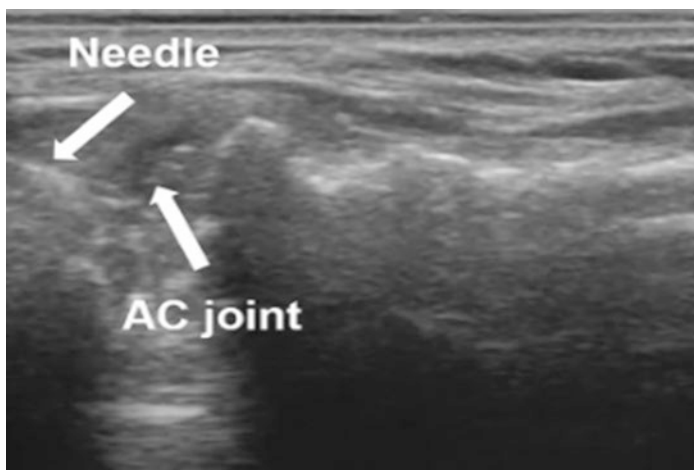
Ultrasound-guided, AC joint injection with needle tip being visualized using the in-plane technique [10]
